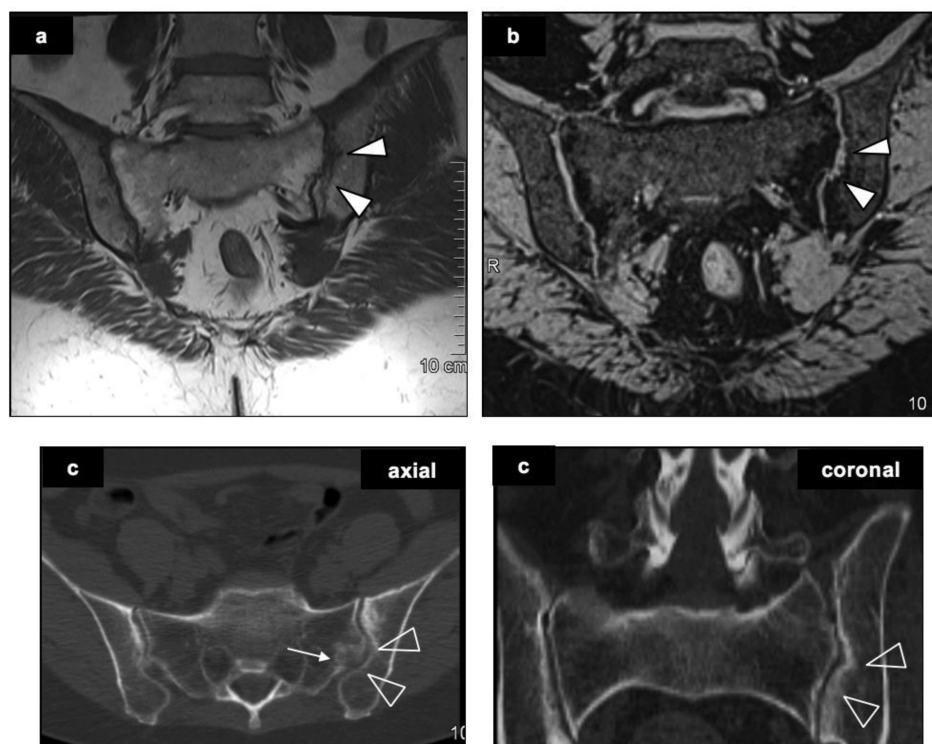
Differences between MRI and CT. SIJ-MRI of a 32-year-old patient with axial spondyloarthritis. A. T1-weighted MRI sequence. B. VIBE sequence. C. CT in axial and semicoronal views. Full arrowheads indicate erosions, seen on both MRI sequences. Empty arrowheads indicate the same areas, but erosions are not visible on CT scan. Arrow indicates area of insertion of ligaments in the sacral bone. VIBE: volumetric interpolated breath-hold examination; MRI: magnetic resonance imaging; CT: computed tomography; SIJ: sacroiliac joints.
